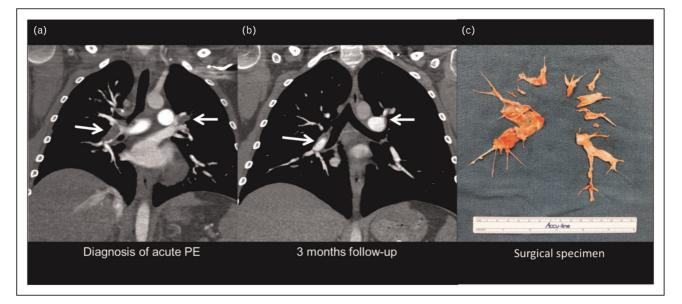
Patients presenting with submassive pulmonary emboli and acute on chronic pulmonary embolism. (a) CT scan on initial presentation demonstrates acute pulmonary emboli along the descending branch of the right pulmonary artery. (b) After 3 months of anticoagulation, the clot burden has decreased, but the chronic component of the disease remains present and pulmonary hypertension was documented on right heart catheterization. (c) Pulmonary thrombo-endarterectomy was performed.
